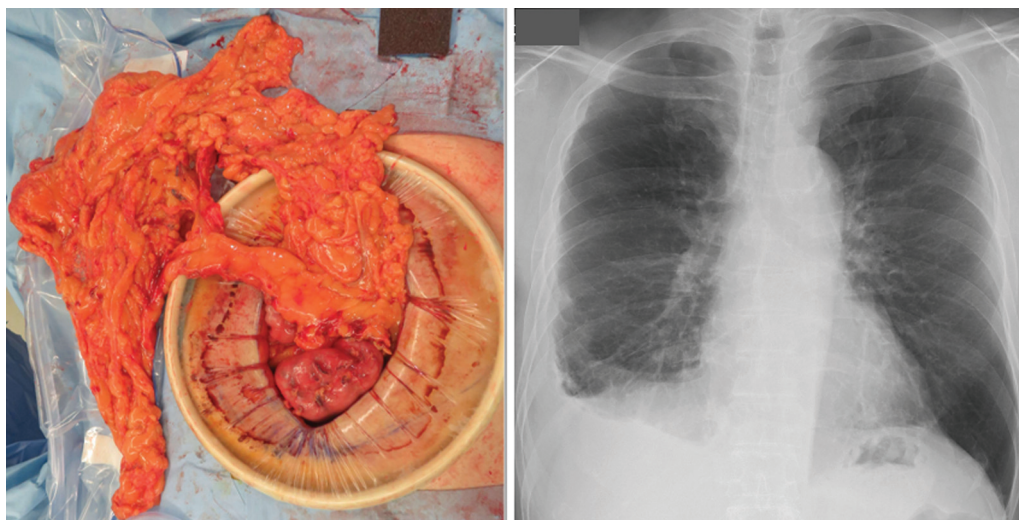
Harvested pedicled omentum. Chest radiograph after filling of the pedicled omentum.
